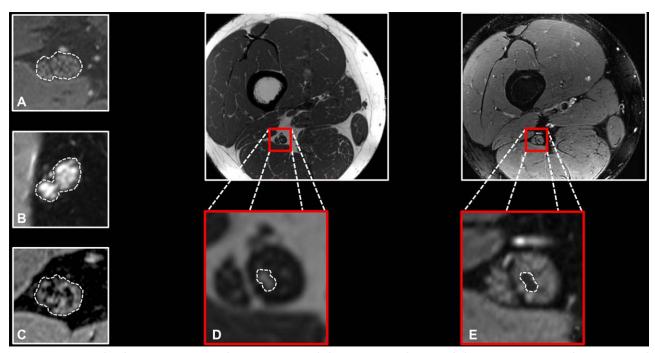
T2-weighted (T2w) sciatic nerve lesions in type 1 diabetes (T1D) and type 2 diabetes (T2D). (A) Regular nerve signal of a 35-year-old male T1D patient without signs of diabetic neuropathy (neuropathy symptom score [NSS] = 0, neuropathy disability score [NDS] = 2, HbA1c = 5.7%, high-density lipoprotein [HDL] = 95mg/dl, triglycerides = 41mg/dl). (B) T2w-hyperintense lesions in a 25-year-old female T1D patient with severe diabetic neuropathy (NSS = 6, NDS = 8, HbA1c = 8.7%, HDL = 81mg/dl, triglycerides = 116mg/dl). (C) T2w-hypointense lesions in a 56-year-old T2D patient with severe diabetic neuropathy (NSS = 7, NDS = 6, HbA1c = 6.7%, HDL = 30mg/dl, triglycerides = 492mg/dl). (D, E) T2w-hypointense lesions in the sciatic nerve are T1w hyperintense. [Color figure can be viewed at www.annalsofneurology.org]
